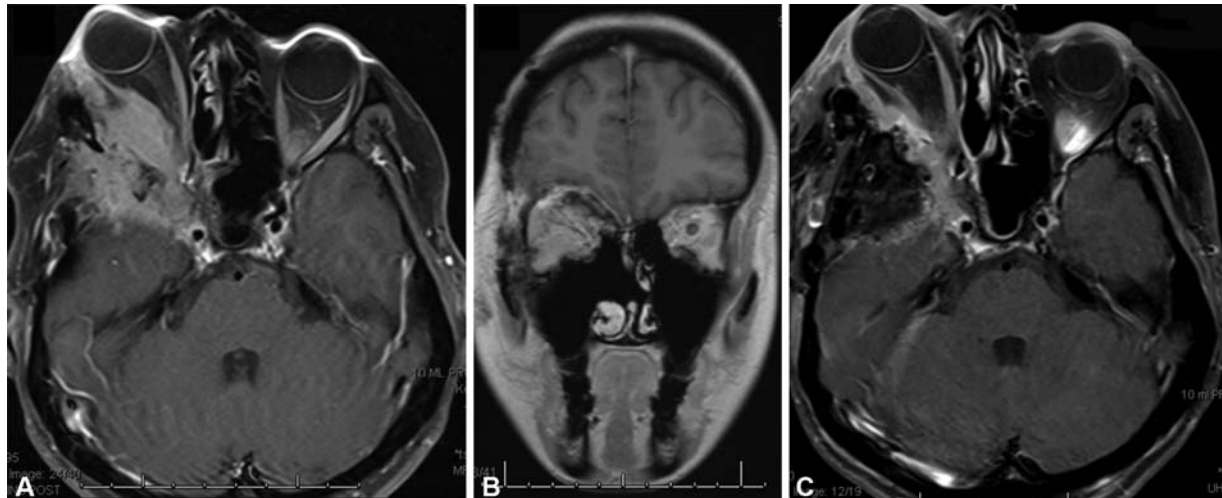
Preoperative images (A, axial and B, coronal postcontrast, T1-weighted magnetic resonance imaging [MRI]) of a 47-year-old woman with a recurrent spheno-orbital and cavernous sinus meningioma with progressive visual loss demonstrate orbital involvement with soft tissue, optic nerve compression, and proptosis. The cavernous sinus component was asymptomatic, and the patient had intact oculomotor function. She underwent a right frontotemporal resection of the orbital tumor with decompression of the orbital contents. The lateral wall of the right cavernous sinus was removed, but no intracavernous tumor was resected given she still had intact binocular vision (C, postoperative axial postcontrast, T1-weighted MRI). Postoperatively, she had improvement in her vision, and subsequently she underwent radiation therapy of the orbit and cavernous sinus.
